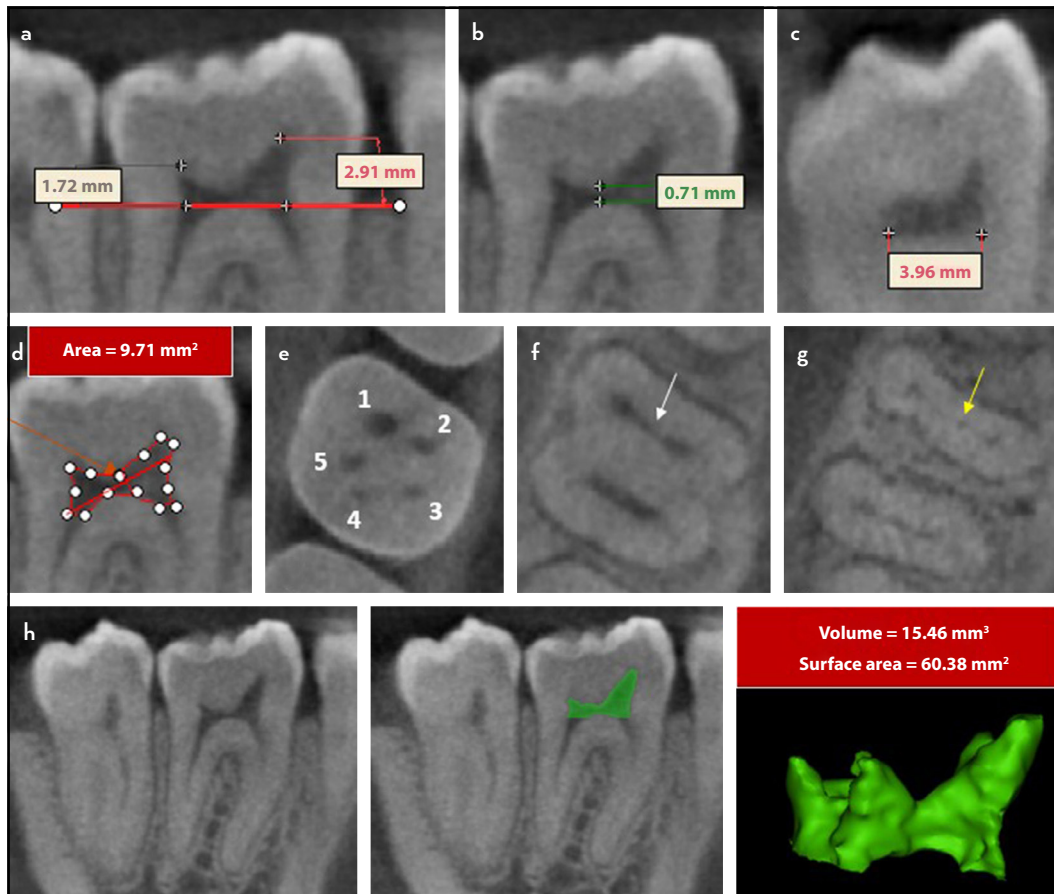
2D and 3D morphological measurements of the pulp chamber in a mandibular first molar scanned using CBCT. (a) Distance between highest point of the pulp chamber floor and highest point of the pulp horn (sagittal view). (b) Distance between lowest point of the roof and highest point of the pulp chamber floor. (c) Bucco-lingual width of the pulp floor. (d) Pulp chamber area. (e) Number of the pulp horns (five). (f, g) Association between the presence of isthmus in the pulp chamber floor between the mesio-buccal and mesio-lingual canals (f) with the occasion of middle mesial canals (g). (h) Volume and surface area of a 3D reconstructed image of the coronal pulp tissue from a CBCT scan
